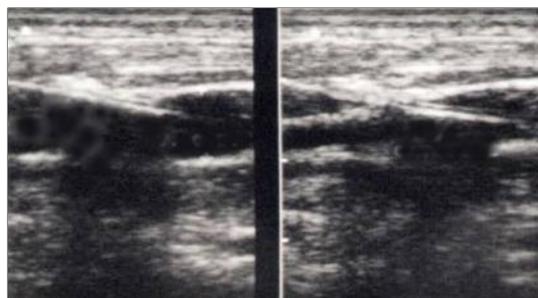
Central Vein Catheterization. Thanks to a 10 MHz ultrasound probe, the needle can be followed into the external jugular vein lumen, during cannulation.
